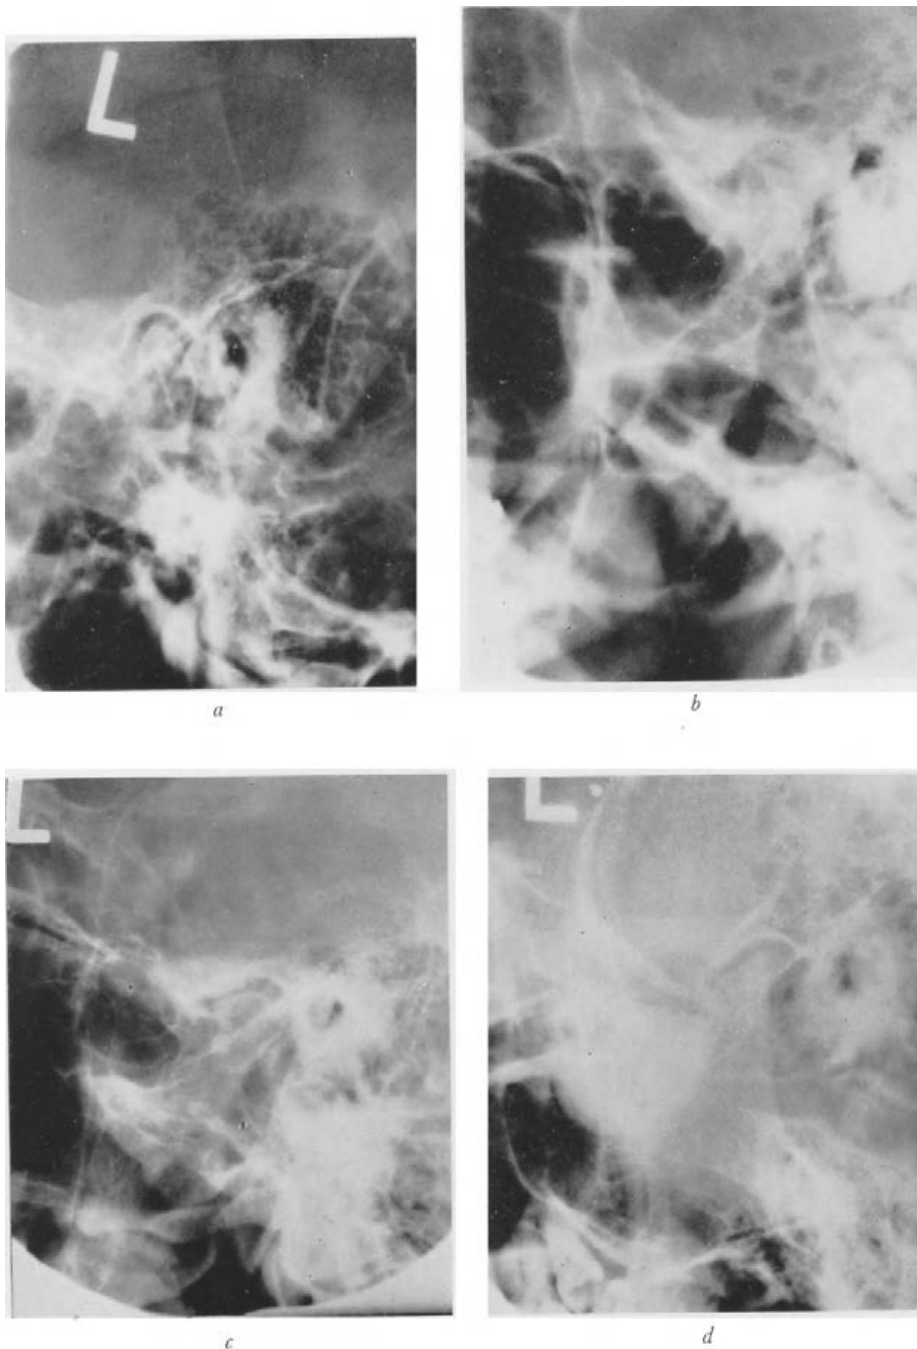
Condyle X-rays. a, Space wider than normal. b, Space more closed. c, Flattening of fossa and condyle with sclerosis. Lipping of condyle. Changes seen in osteoarthritis. d, Long standing destruction of condyle, suggestive of rheumatoid arthritis with possible osteoarthritis superimposed. See p. 61 for normal outlines. (By courtesy of Dr. J. J. Prior at the Eastman Dental Hospital.)
